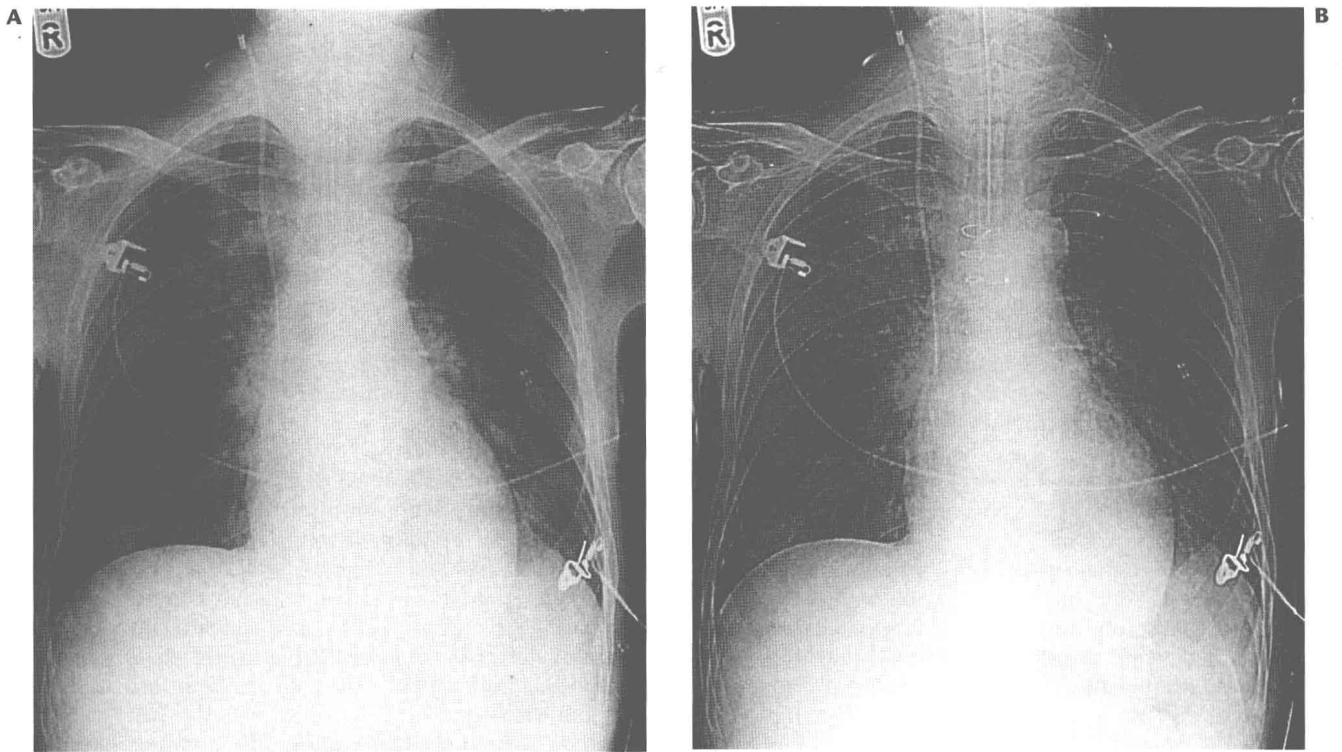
A portable radiograph (phosphor plate) – A, manipulated to resemble a conventional radiograph and B, digitally processed to give wider latitude and edge enhancement.
